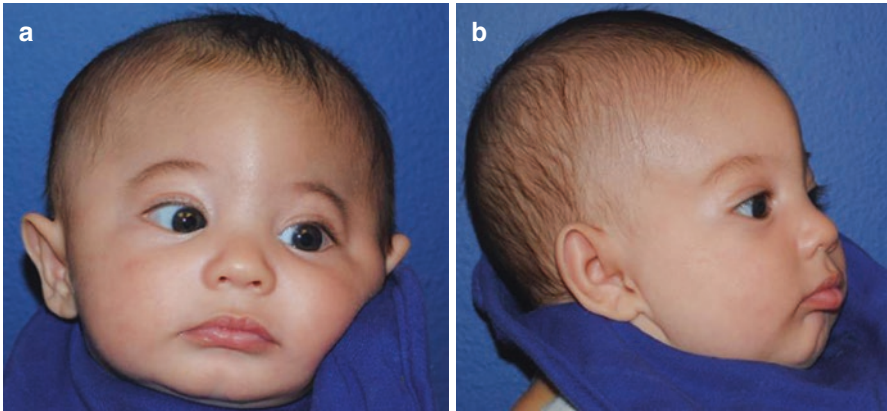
Two-month-old male with metopic craniosynostosis (a, b). Preoperative CT scan (c, d). Postoperative CT scan demonstrating osteotomies and position of distraction devices (e, f). One-year follow-up photos (g–i)
